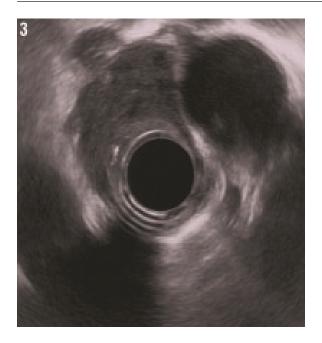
Endosonographic Image showing esophageal wall thickening with periesophageal enlarged lymph nodes.
